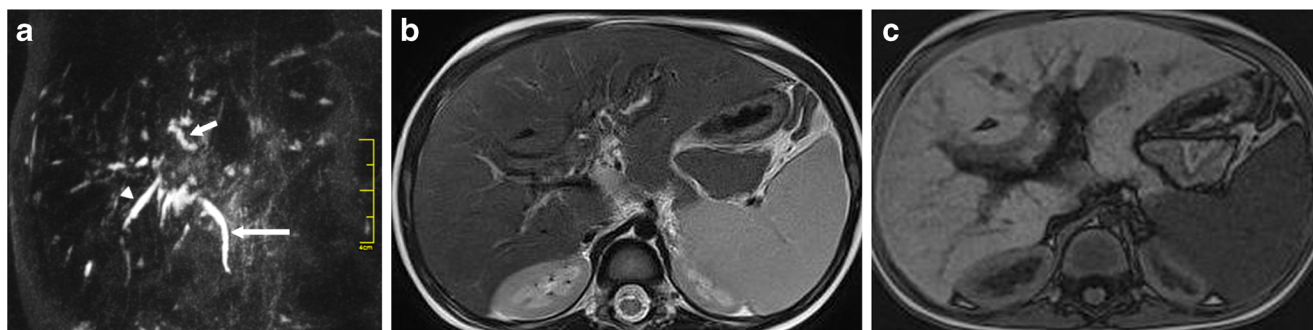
MRCP and MRI in a 25-month-old boy (patient 5). a MRCP image demonstrates total interruption of the common hepatic duct and its first-order branches. Segmental dilatation of the peripheral bile ducts in both the left and right lobes can be seen. Note the common bile duct (*long arrow*), the left hepatic duct branch (*short arrow*) and the right hepatic duct branch (*arrowhead*). b The periportal lesions show slightly
